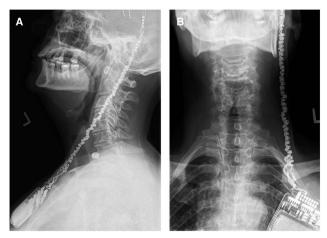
Lateral (A) and AP (B) x-rays showing extensive twisting of DBS extension leads.
